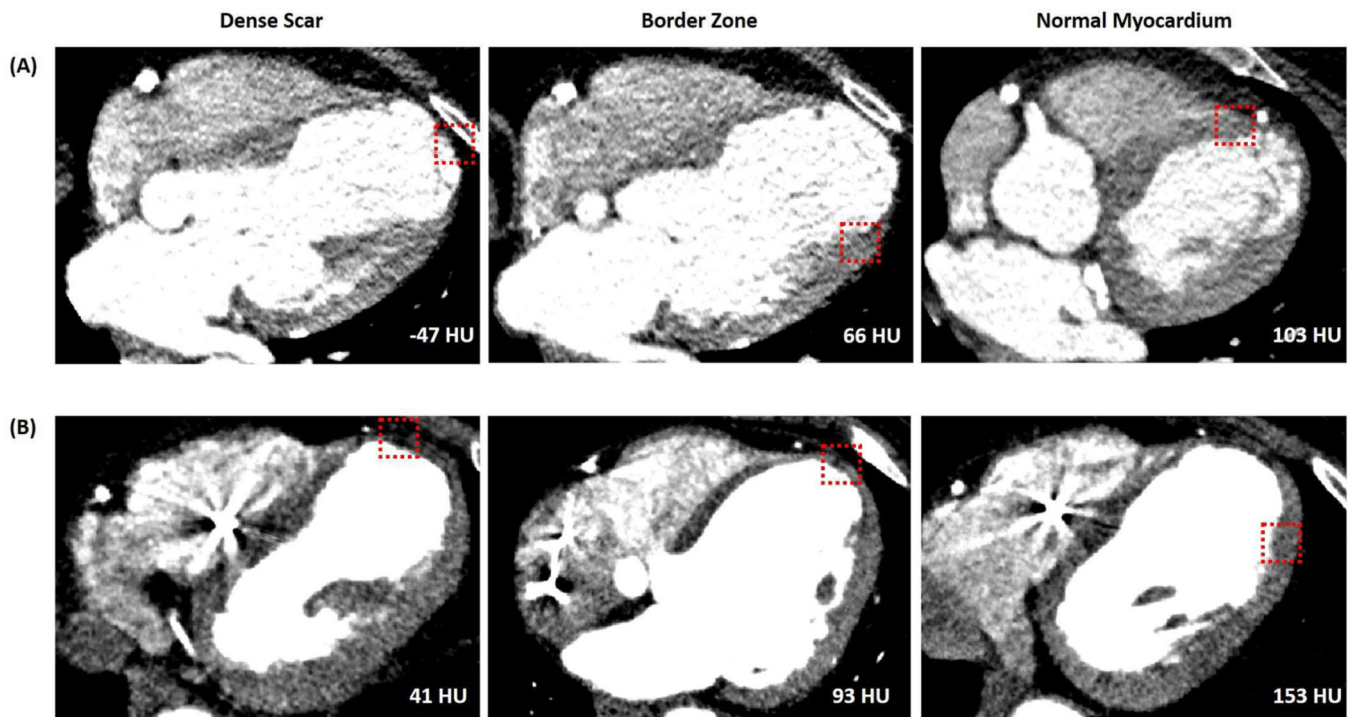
Examples of Myocardial Characteristics on CE-CT at Scar, Border Zone, and Normal Myocardium
